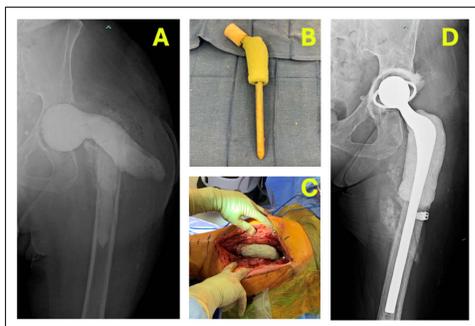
A 75-year old woman with a history of two antibiotic loaded spacers for periprosthetic joint infection (PJI). Preoperative anterior-posterior (AP) radiograph (A) shows obliquely oriented proximal spacer indicative of construct fracture. Patient underwent spacer removal with implantation of new spacer (B) pictured on operating table. Intraoperative photo (C) depicts spacer following placement in patient's hip. Postoperative AP radiographs at 1 year follow-up (D) demonstrate Prostalac type left hip spacer with unchanged alignment and without radiographic complications.
